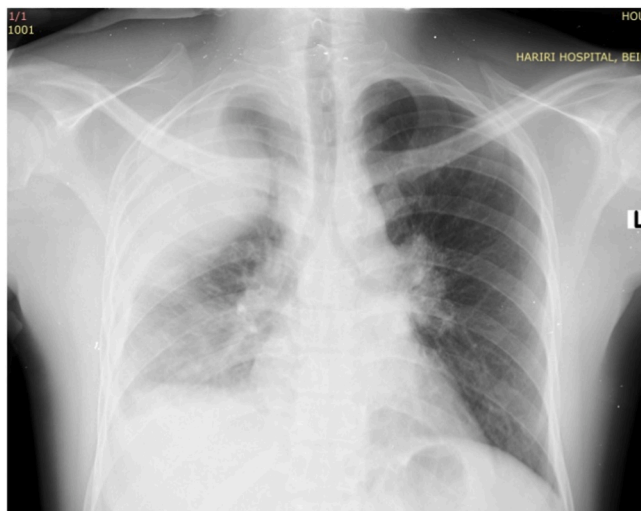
A chest X-ray revealed a 10 × 8.5 cm opacity overlying the right upper lobe, with mild right pleural effusion and enlarged left hilum.
